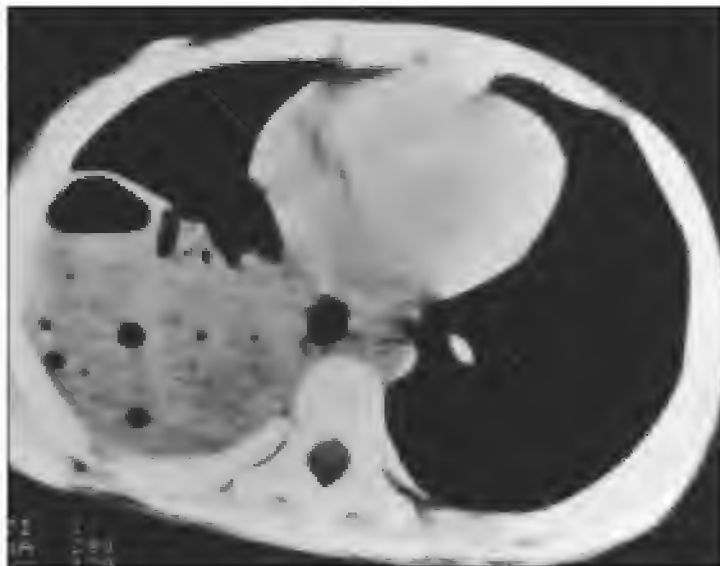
Computed tomography shows the size and extent of an empyema with multiple air and fluid filled spaces.
